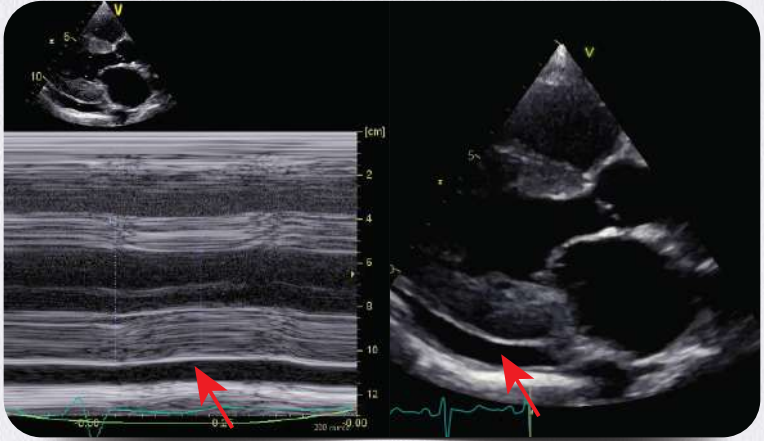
Pericardial effusion- Parasternal long axis showing pericardial effusion posterior to the left ventricle (red arrows).
